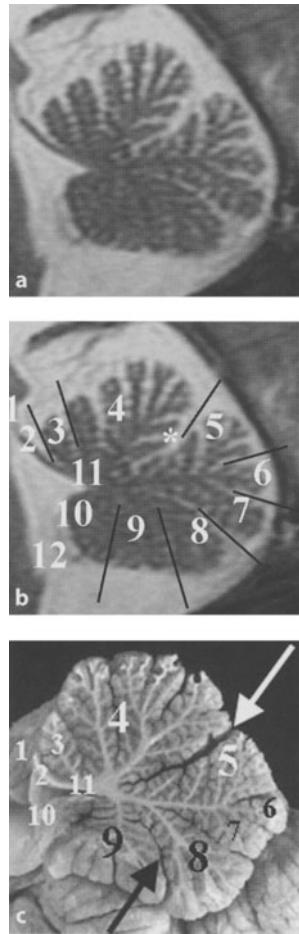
Normal radiology and anatomy. a Sagittal T2 MRI of normal vermis. b Subdivision into lobules. The asterisk (*) is in the upper main fissure (fissura prima, primary fissure). The lower main fissure (fissura secunda, secondary fissure), between the pyramis and the uvula, is usually less visible on MRI. c Anatomical view on a sagittal midline cut: note the primary fissure (white arrow) and the secondary fissure (black arrow). 1, Superior medullary velum; 2, lingula; 3, lobulus centralis; 4, culmen; 5, declive; 6, folium; 7, tuber; 8, pyramis; 9, uvula; 10, nodulus; 11, fastigium; 12, Magendie foramen
